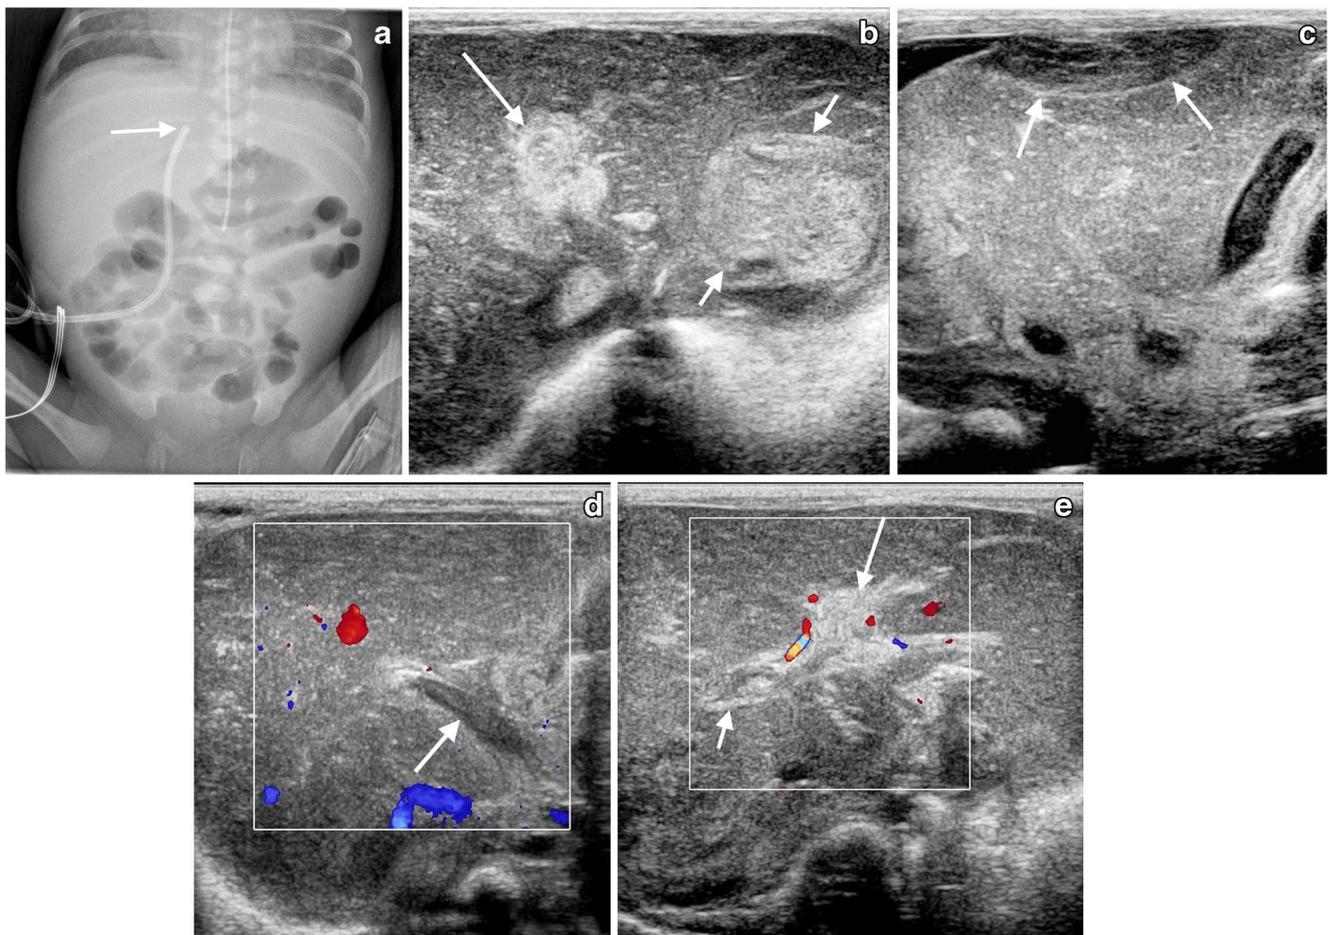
Parenteral nutrition extravasation in a 25-week-gestation premature girl. a Abdominal radiograph at 11 days old shows the umbilical venous catheter tip (*arrow*) in a low position overlying the liver parenchyma. b Transverse ultrasound image of the upper abdomen at 12 days old demonstrates an echogenic area within the left lobe of the liver, part of a large intrahepatic collection (*short arrows*). An echogenic collection in the right lobe of the liver surrounds the portal vein, which is thrombosed (*long arrow*). Central collections within the liver are thought to be related to direct trauma caused by the indwelling umbilical catheter.
